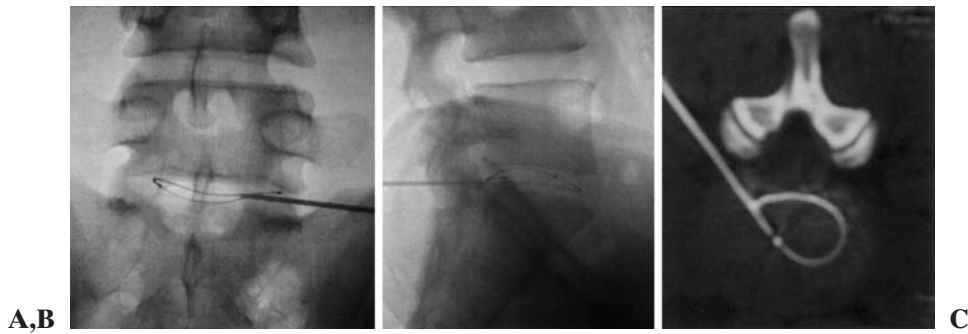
L5/S1 intradiscal electrothermal therapy (IDET) was performed in the patient. A Anteroposterior and B lateral fluoroscopic images show proper catheter placement. C Computed tomography during IDET in case 1, showing proper catheter placement
